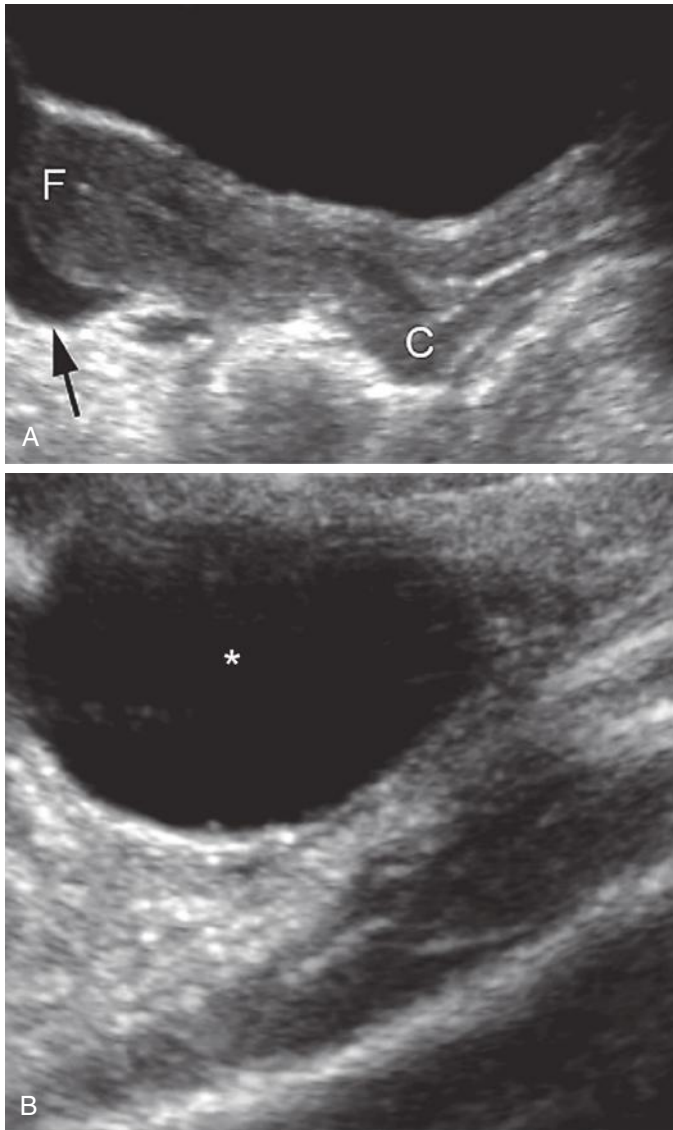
Estrogen-secreting ovarian cyst in a 5-year-old girl with premature breast development and vaginal bleeding. A, Sagittal ultrasound image of the pelvis depicts a peripubertal appearance of the uterus, with relative prominence of the uterine fundus (F) compared to the cervix (C). There is a small amount of free pelvic fluid (*arrow*). B, Sagittal ultrasound image of the right ovary reveals a large (5 cm diameter) simple cyst (*asterisk*).
